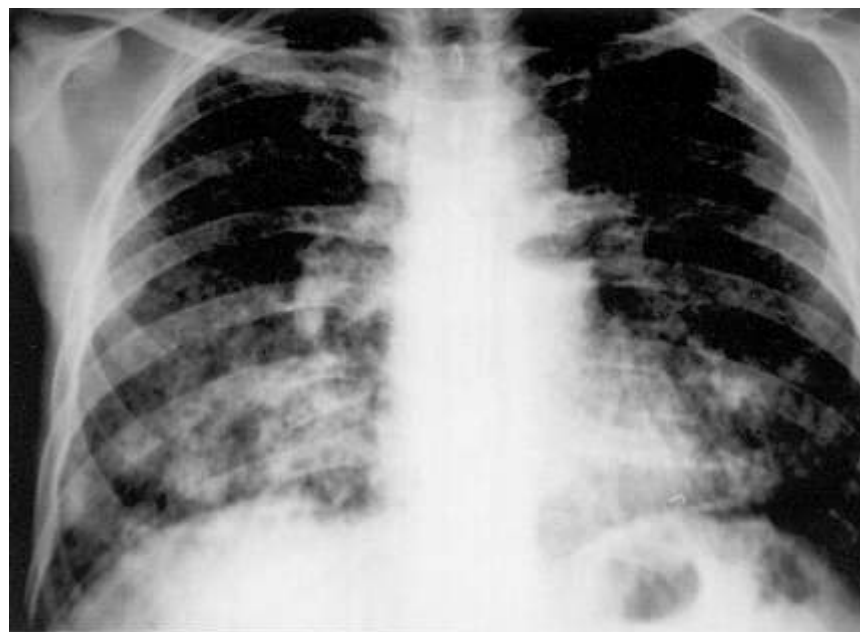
Chest X-Ray: diffuse reticulonodular interstitial pattern predominantly in both pulmonary bases.
